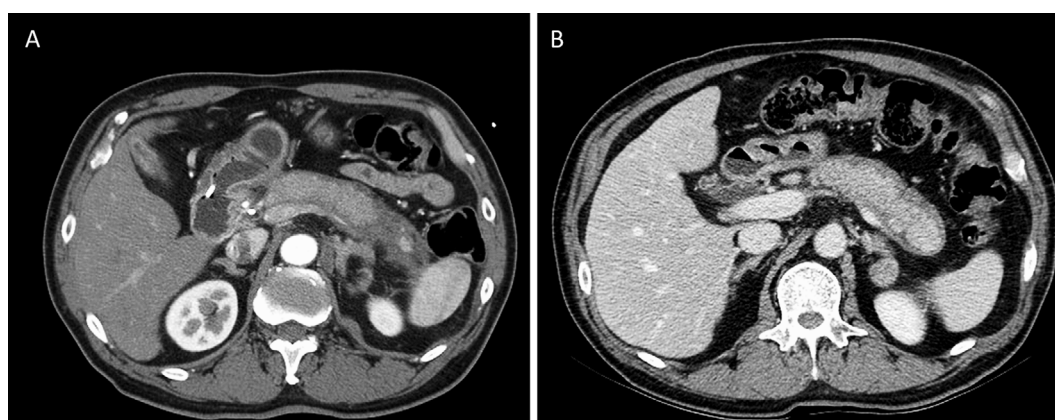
Enhanced CT of pancreatic parenchymal imaging showing diffuse swelling and a capsule-like rim in (A) the elder brother and (B) the younger brother.
